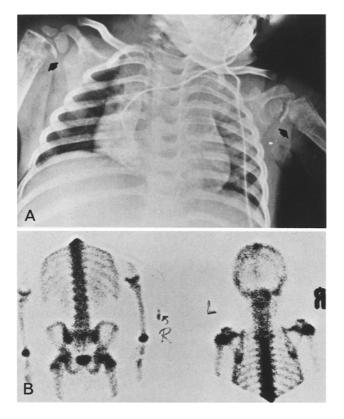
False-negative scan resulting from metastatic neuroblastoma. A Radiograph reveals bilaterally symmetrical destruction of proximal humeral metaphyses (*arrows*). B Resultant activity is difficult to distinguish from normal increased activity in unfused epiphyses
